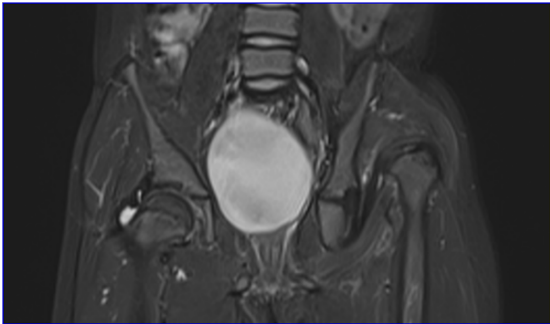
Coronal FST2WI MRI of a male child shows left DDH.
